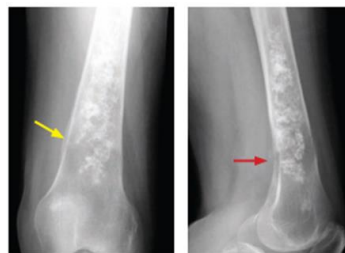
Chondrosarcoma on Frontal and Lateral Radiographs of the Distal Femur
